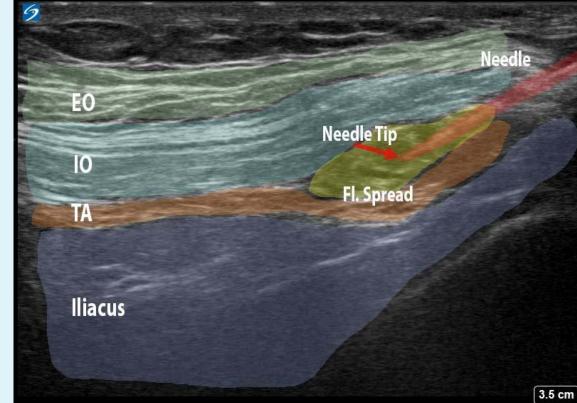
Ultrasound image showing anatomy after IL/IH block with needle and local anesthetic fluid spread visible.
